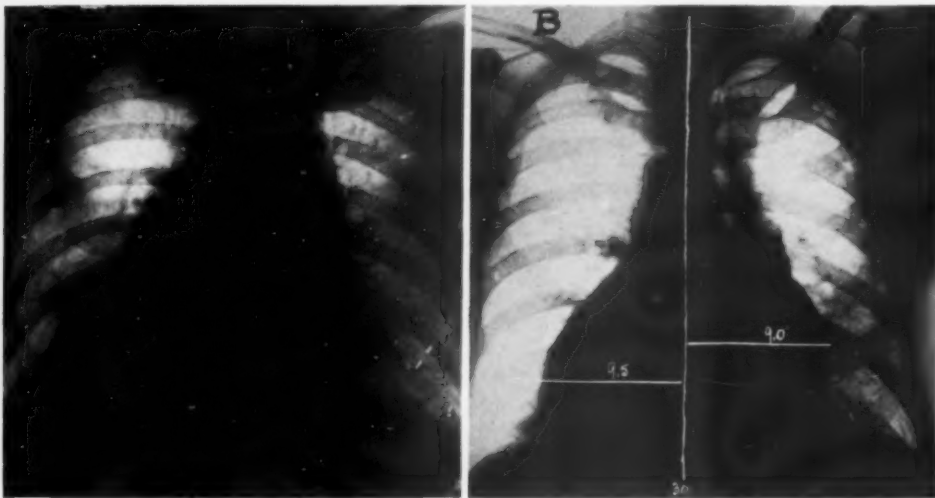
Heart films made with portable equipment. A—taken 3-27-35, patient semi-recumbent, 30 inch distance, 3 weeks after acute coronary thrombosis, showing pericardial effusion. B—taken the following day, 2 hours after withdrawal of 500 c.c. of pericardial fluid, erect position, 5 ft. distance, transverse "cardiac" diameter 18.5 cm., internal chest diameter 30 cm., CT ratio 60 per cent.
